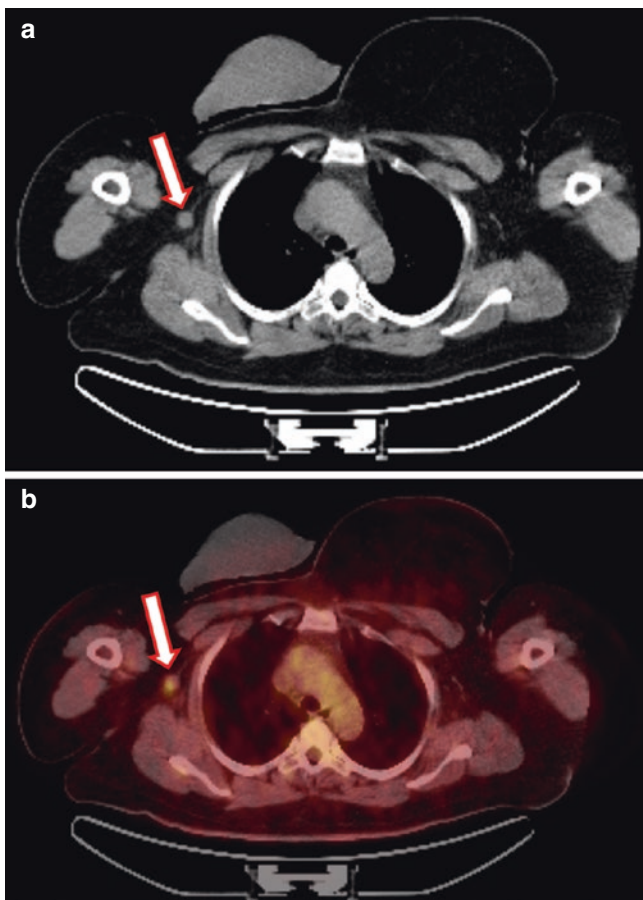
CT and PET fusion imaging (a, b) of a 45-year-old woman with an isolated axillary nodal recurrence 3 years after mastectomy with a negative SLNB. PET-CT modality revealed an increased uptake value of F-18 fluorodeoxyglucose (SUVmax: 16.2)
